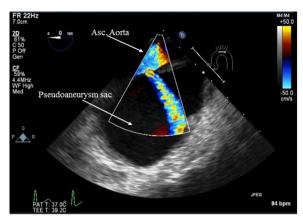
Midesophageal ascending aorta long-axis view with color-flow Doppler. Flow is visualized from the ascending aorta into the pseudoaneurysm sac
